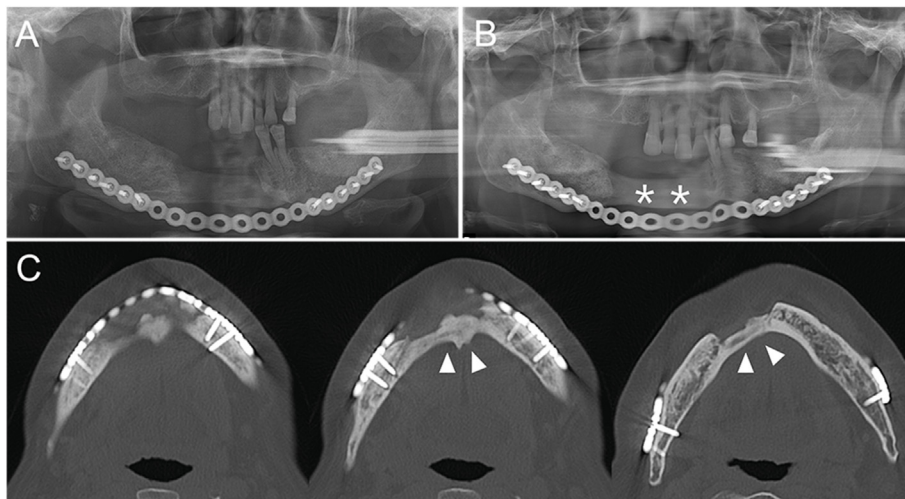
Postoperative radiographs of Case 1. (A) Panoramic view at one year after surgery, (B) panoramic view at three years, and (C) computed tomography images at two years postoperatively showing progressive bone healing with formation of a bone bridge (asterisk and arrowhead) restoring mandibular continuity.
